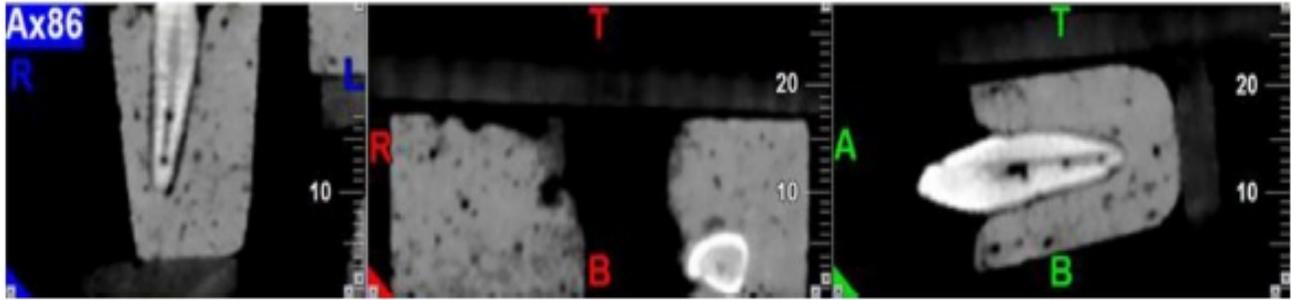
Radiographic view of internal root resorption
